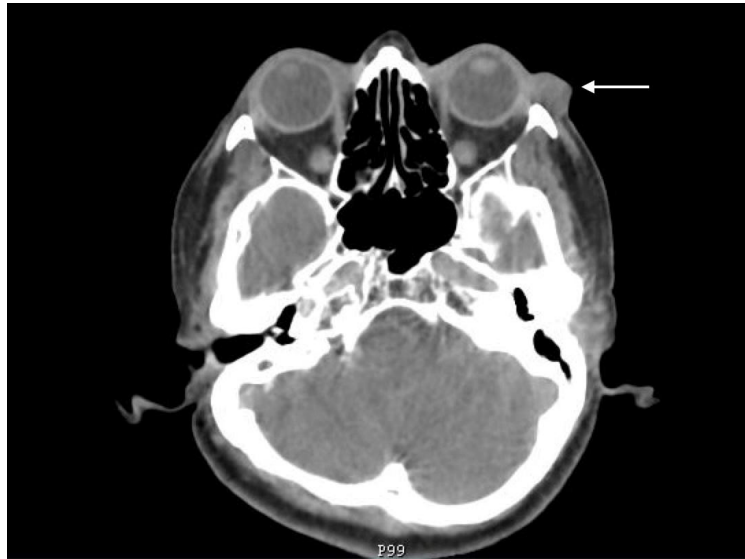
A contrast enhanced axial CT Scan section demonstrating a well-defined, hypodense, non-enhancing, solitary lesion [arrow] adjacent to the outer canthus of the left eye, with no underlying bone involvement
